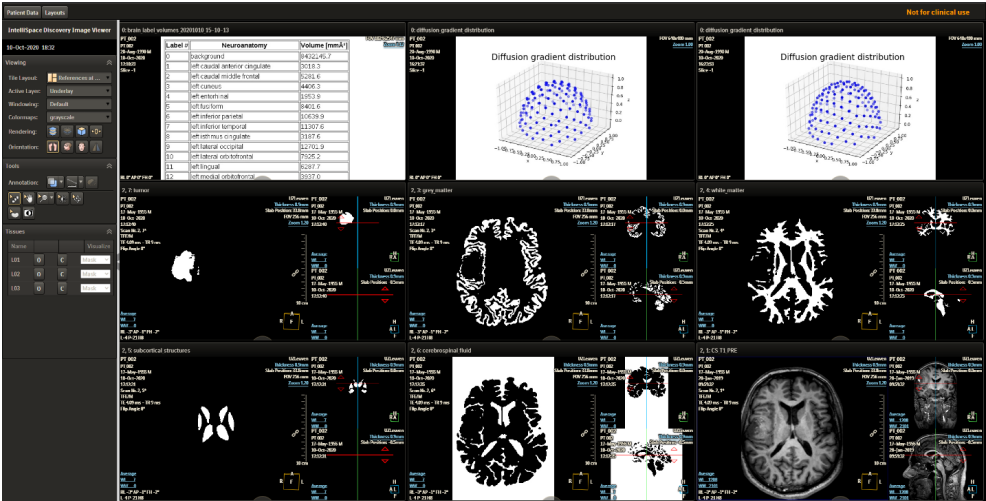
Outcomes from remote image processing returned to ISD over the computation node framework. This active view shows labels from the segmentation of the lesion and all brain structures, graphs of the diffusion MR imaging gradients in each HARDI acquisition to check for uniform distribution, and a report of brain region volumes for this patient case. Image courtesy: Philips ICAP Aachen, Germany.
